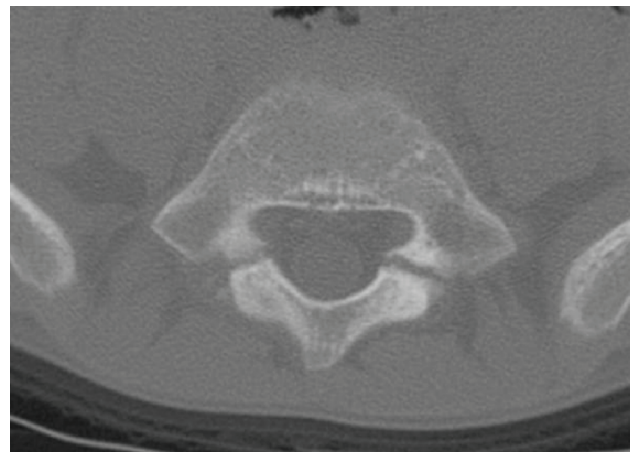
CT scan of the transitional lumbosacral (L5) vertebra.
